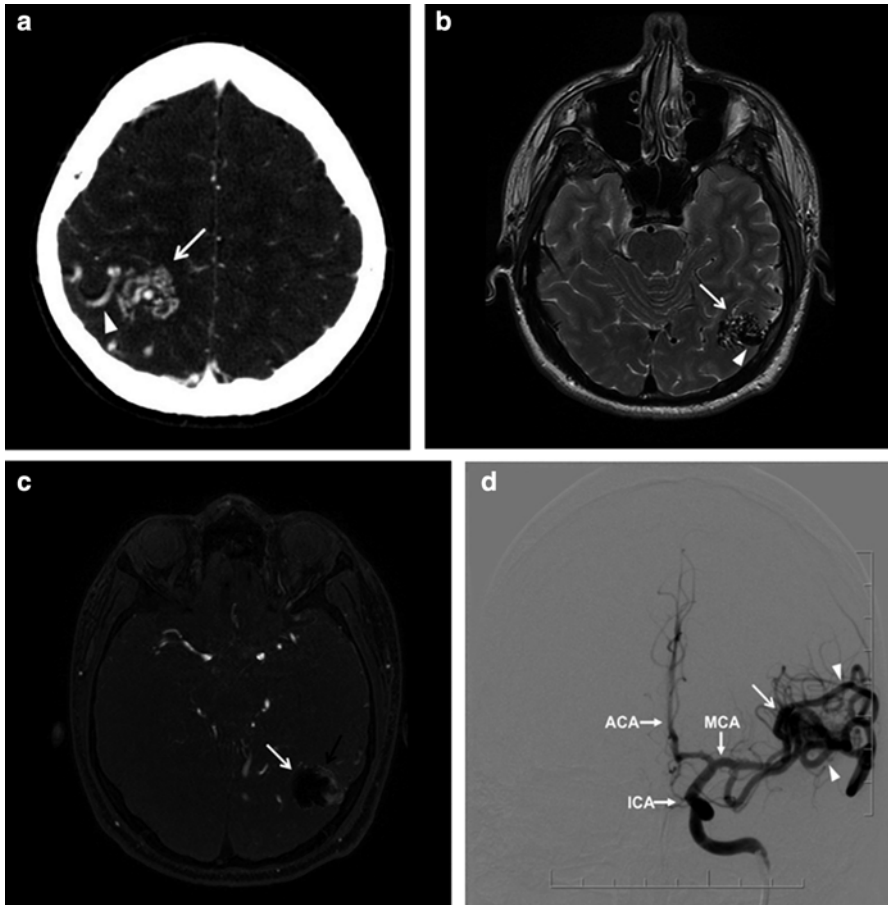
Diagnostic imaging of brain arteriovenous malformations. (*top left*) CT angiography, scan showing a hyperdense mass of enlarged feeding arteries (*arrow head*) supplying the nidus (*open white arrow*) (*top right*) MRI, T2 weight image. The nidus appears on the scan as a hypointense mass with a feeding artery (*bottom left*) MR angiography, scan demonstrating a residual filling (*open black arrow* pointing to the hyperintense area) of the nidus after endovascular embolization of AVM (hypointense region marked with *white open arrow*) (*bottom right*) Digital subtraction angiogram demonstrates a blood supply (feeding arteries) of the AVM (*open white arrow*) from branches of the middle cerebral artery (*arrowheads*)
